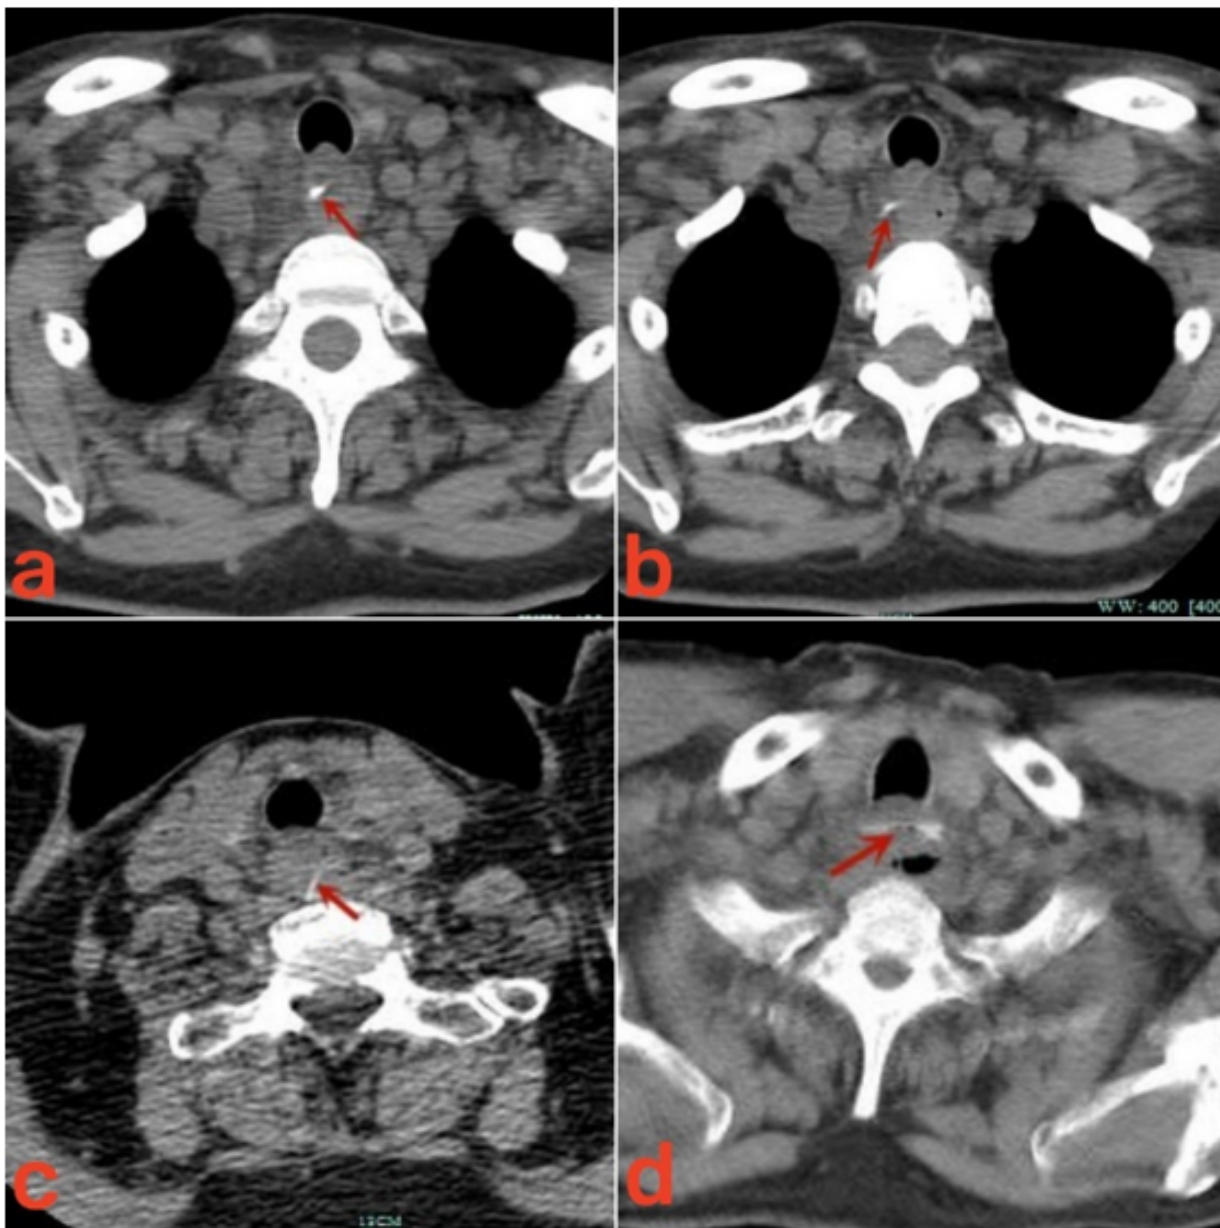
Axial plan of chest computed tomography scans with esophageal foreign body (the red arrows).
